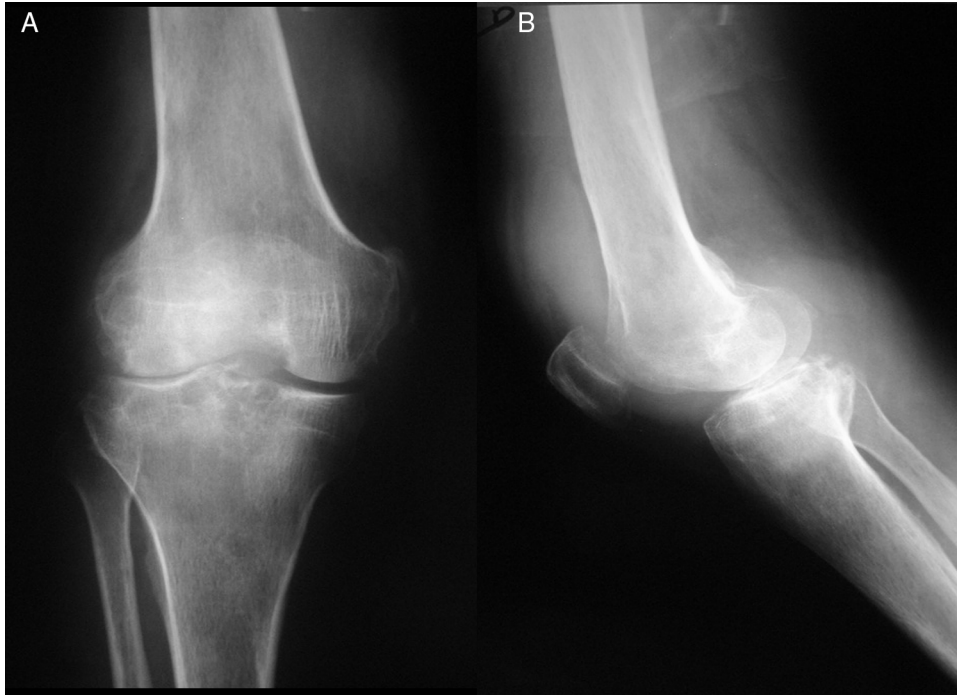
Knee radiograph of a diffuse pigmented villonodular synovitis of the knee in (A) antero-posterior and (B) profile, evidencing areas of bone destruction.
